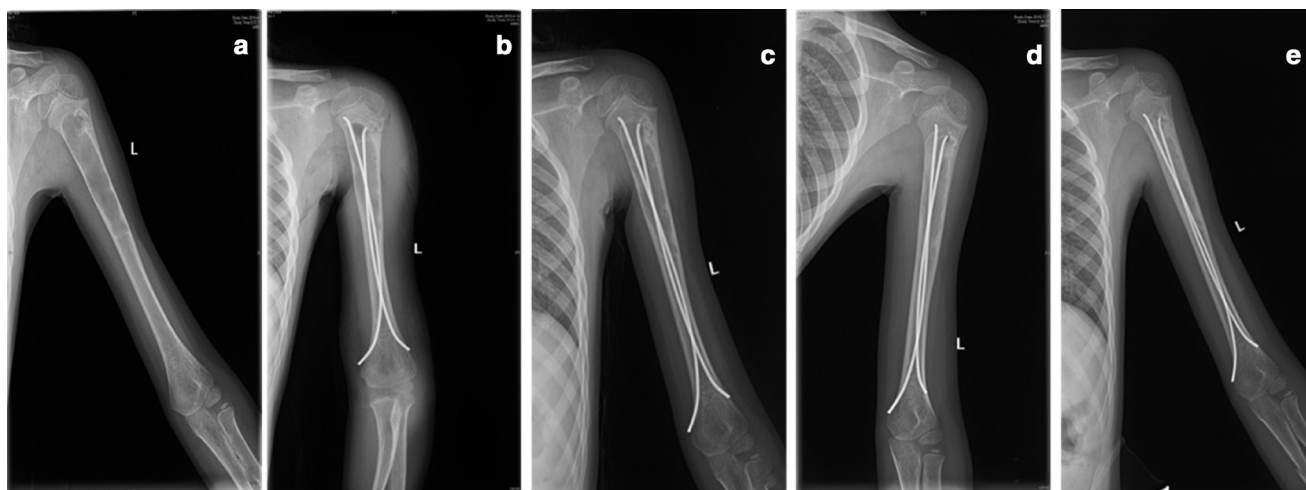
Male aged seven years and seven months, unicameral bone cyst at left humerus proximal, two injections, partially healed (Capanna II). Another injection of methylprednisolone acetate administered three months after surgery: a) radiograph of left humerus preoperative; b) radiograph after one day; c) radiograph after two months; d) radiograph after three months; e) radiograph after six months.
